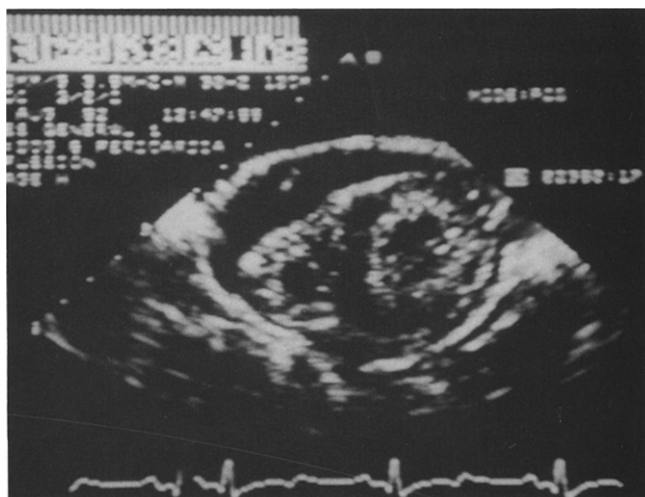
Two-dimensional echocardiographic short-axis view of a pericardial effusion with the corresponding three-dimensional positional data (digitally encoded in the upper left corner). Note the asymmetry of the effusion, which is predominantly anterior.
